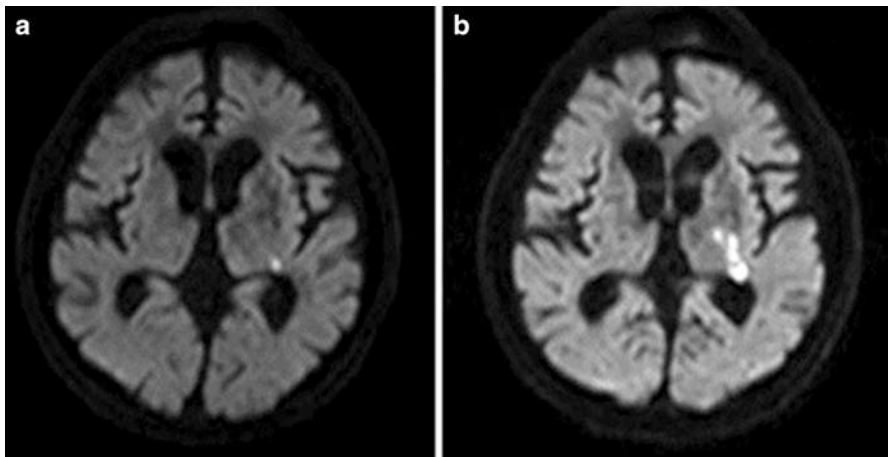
Diffusion-weighted MRI of a 67-year-old man with no demonstrable neurologic deficits before off-pump CABG. (a) Preoperative MRI scan revealed small diffusion abnormality on the left posterior limb of the internal capsule. (b) Another scan performed 5 days after surgery demonstrated that size of diffusion restriction lesion had increased; the patient had dysarthria and right hemiparesis
